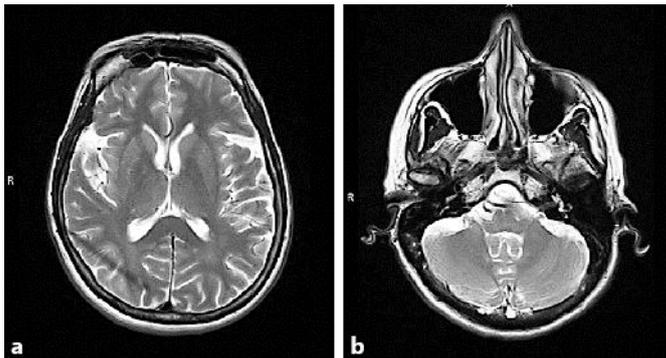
MRI of the brain. No significant cortical (a) or cerebellar atrophy (b) is present. The brain stem is normal.
